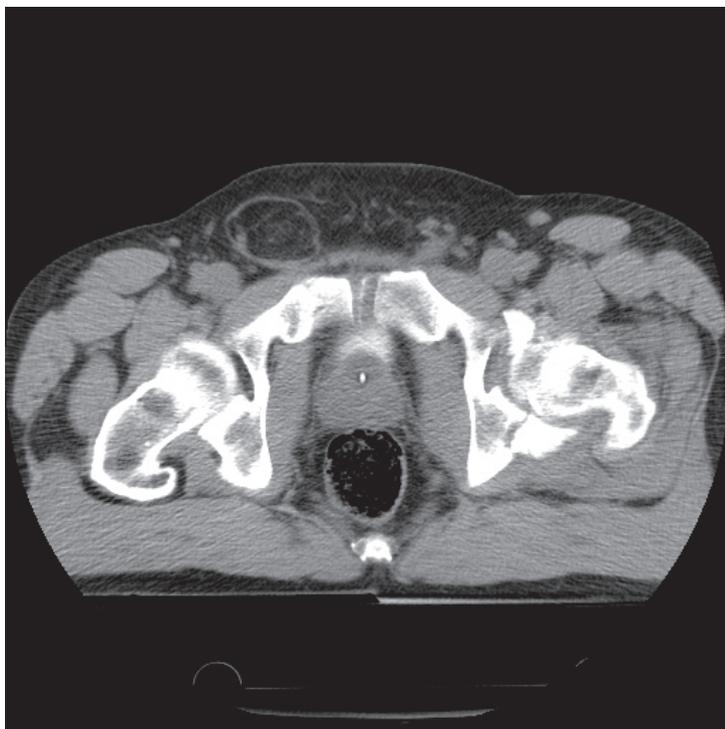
This patient has a left sided comminuted acetabular fracture. The pelvic computed tomography axial image identified a right sided previously undiagnosed inguinal hernia. The inguinal hernia repair can be coordinated at the same anesthesia as for the acetabular reduction and fixation, and using the ilioinguinal exposure.
